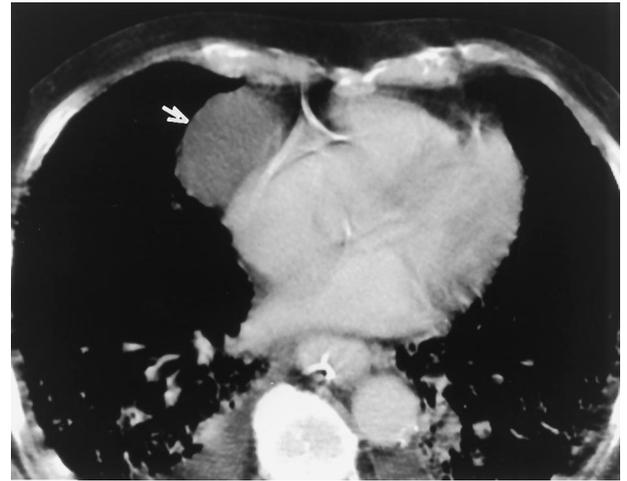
Contrast-enhanced chest CT (mediastinal windows) at the base of the heart in a 54-year-old man with complicated pneumonia. A pericardial cyst (arrow) exhibits water attenuation contents, an imperceptible wall, and contiguity with the heart and anterior chest wall.
